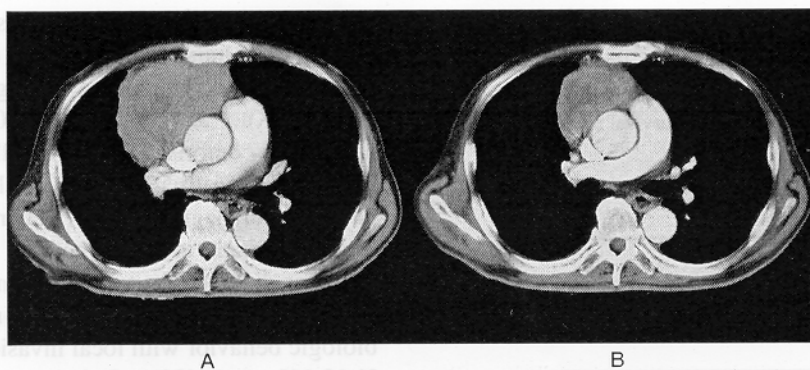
Chest computed tomography (CT) scans of Case 4 before (A) and after (B) induction chemotherapy.
